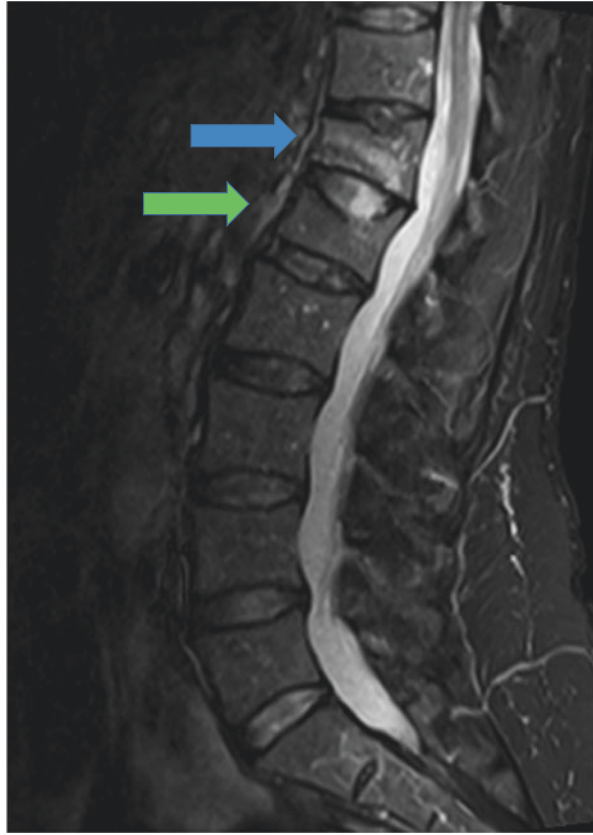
STIR MRI sequence demonstrating increased STIR signal in an acute T12 VCF and normal signal in a chronic L1 VCF
